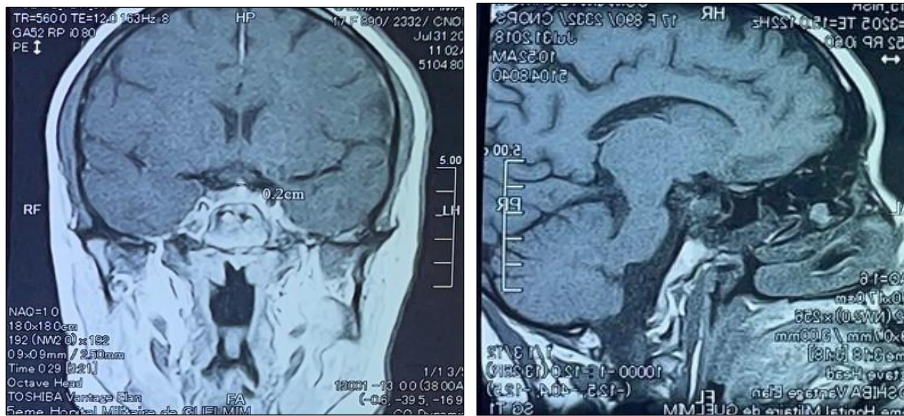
Coronal (c) and sagittal (d) sections of pituitary MRI: 7*5mm left paramedian pituitary microadenoma.
